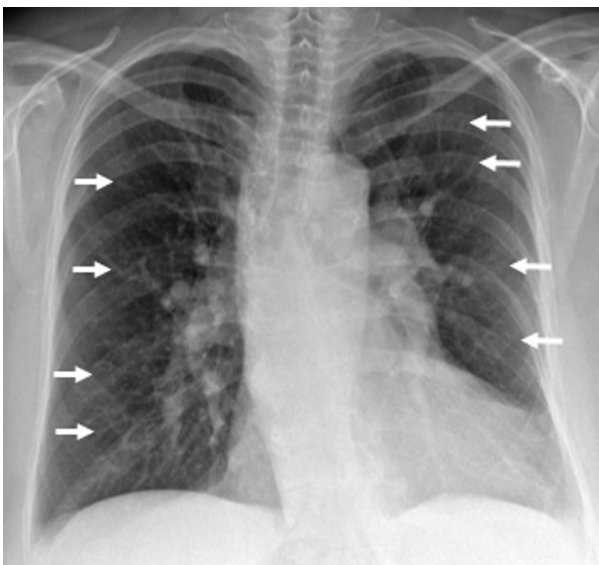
Frontal chest radiograph with plump pulmonary arteries seen coursing to the outer 1/3 of the lung with rapid tapering of vessels consistent with vascular pruning (arrows). The presence of vascular pruning is thought to be associated with vascular remodeling of the pulmonary arteries.
